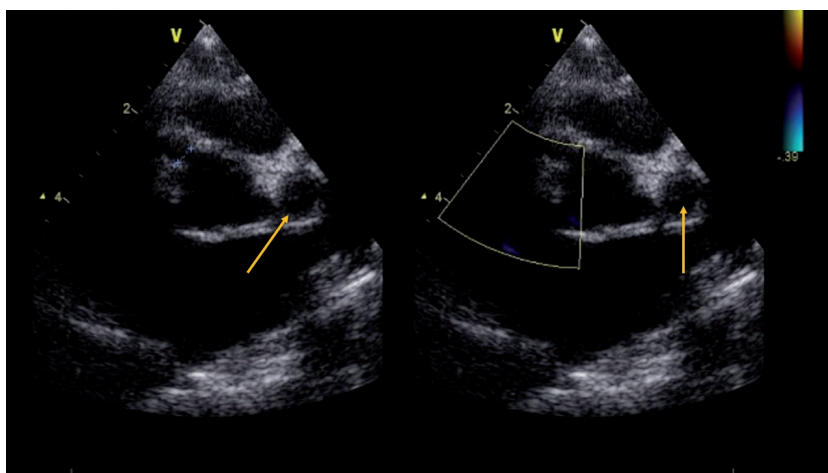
Echocardiography (short-axis view) with coronary artery aneurysm, yellow arrow pointing at coronary artery aneurysm (left anterior descending artery diameter of 10 mm). NÚSCH, a. s., DKC
